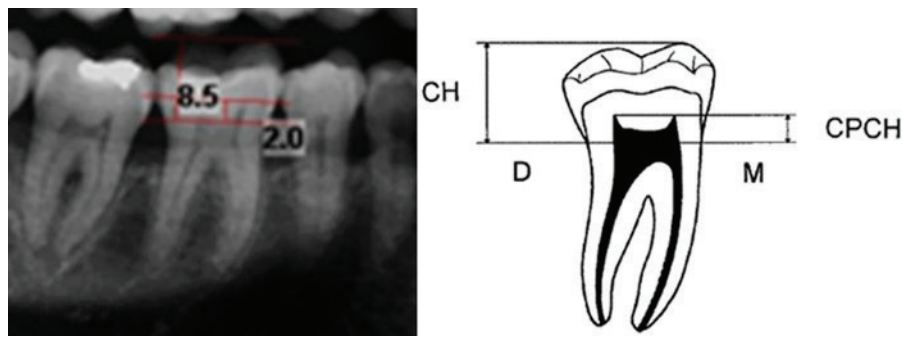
Cropped image of the digital panoramic radiograph showing the Crown Height (CH) and Coronal Pulp Cavity Height (CPCH) measurements.
